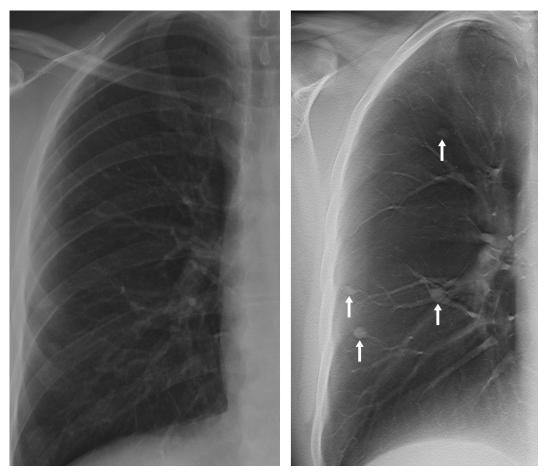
Two images from the same patient. The picture to the left shows a projection image from ordinary chest radiography and the right shows one of the section images from the tomosynthesis examination. Whereas several nodules are clearly visible in the right image, the same nodules are very difficult to discern in the left image. The arrows are inserted by the authors.
